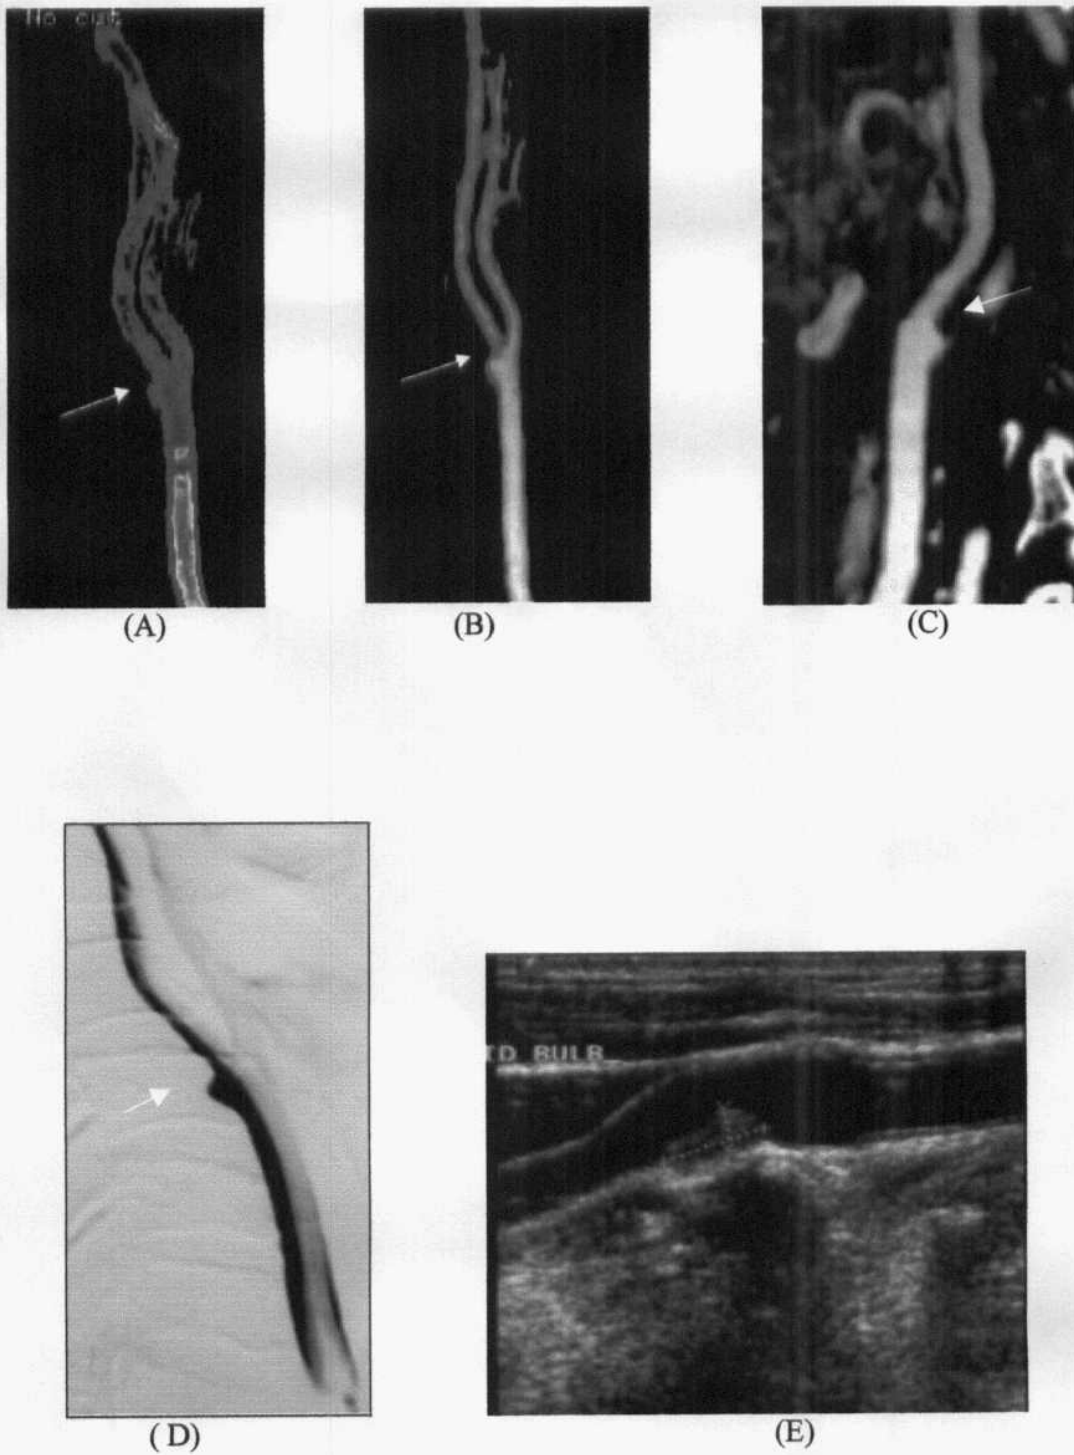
Left internal carotid artery stenosis by transparent (A) and nontransparent VRTs (B), Curved reformat(C) Digital subtraction angiography (DSA) (D), and B-mode ultrasound(E).
